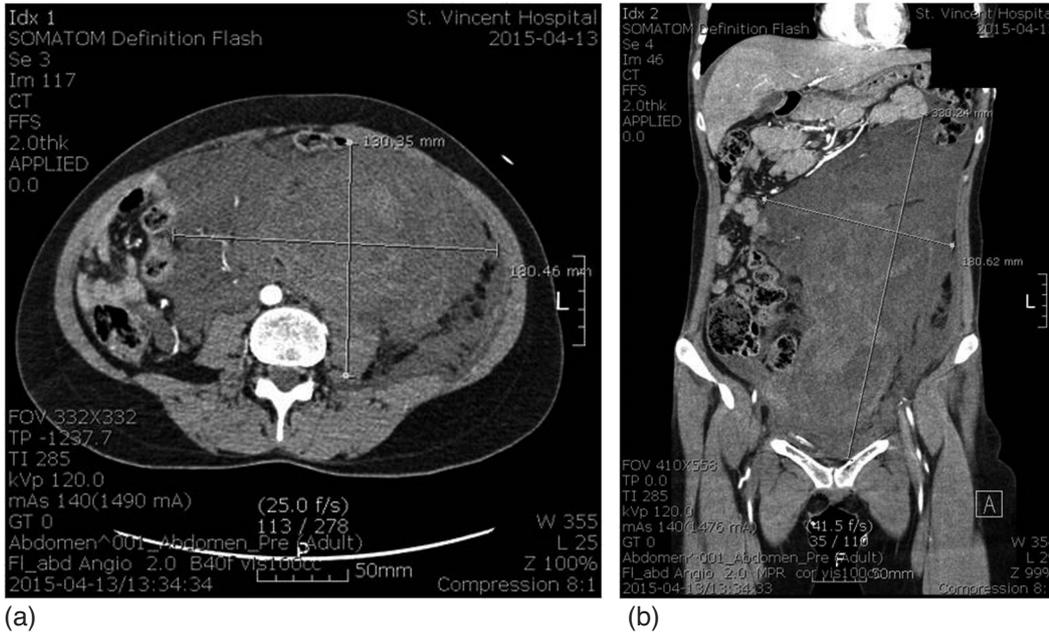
Abdominal and pelvic angiographic computed tomography (CT) before treatment was used to visualize the retroperitoneal hematoma (about 33 × 18 cm in size) from both the axial (a) and coronary (b) views.
